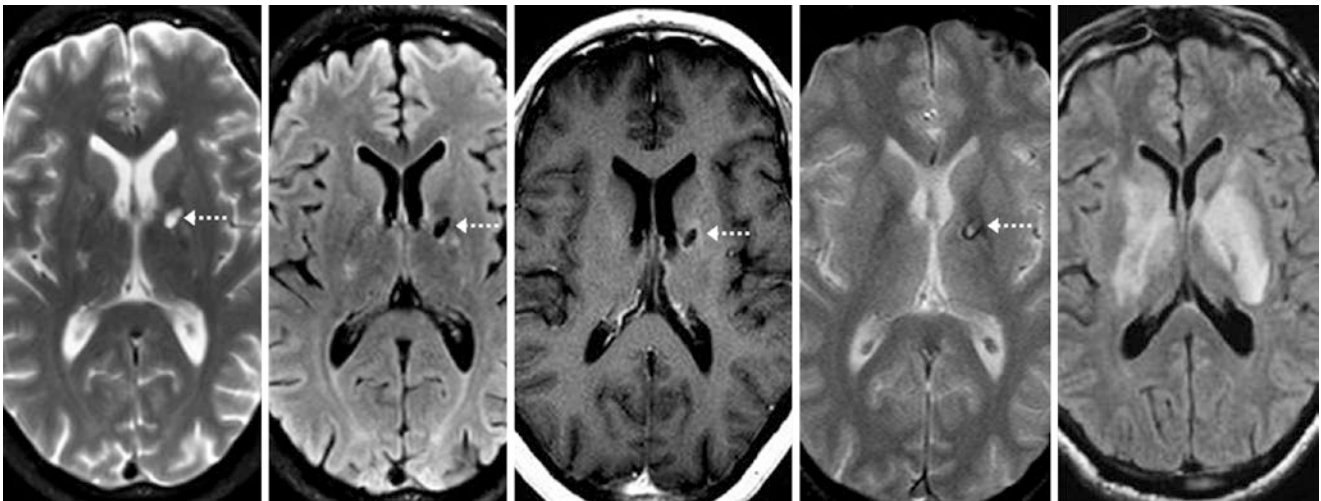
Comparison case of neuro-Behçet syndrome sequela. In a 40-year-old male with prior neuro-Behçet a focal hyperintensity was seen within the left basal ganglia (*dotted arrows*) on a 1.5T MRI with axial T2WI (*left*) and FLAIR (*left middle*), with faint surrounding enhancement on postcontrast T1WI (*middle*) and hemorrhage on GE T2*WI (*right middle*). An MRI 2 years prior at the time of onset of disease showed edema of the basal ganglia on FLAIR (*right*)
